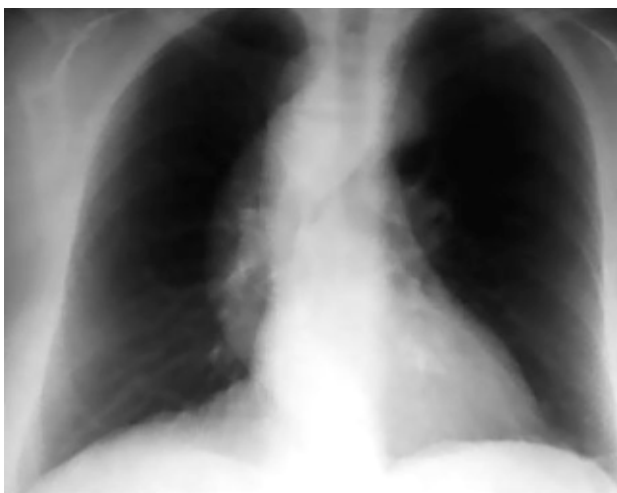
Chest x-ray indicating an aneurysm of the descending aorta.
